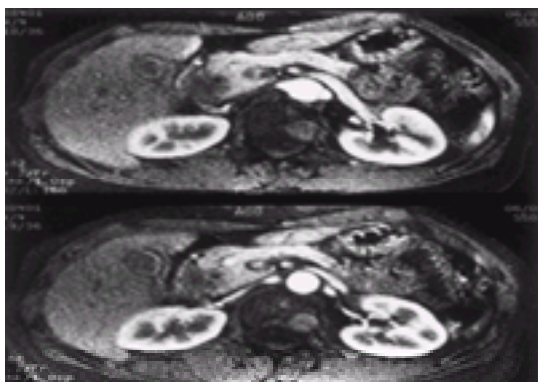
Two T_1 -weighted MR images using contrast enhancement with gadolinium. A mass in the head of the pancreas appears as a hypointense area.
